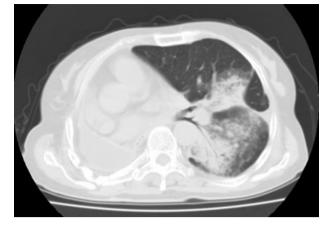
CT scan showing improvement in consolidation after four courses of chemotherapy.
